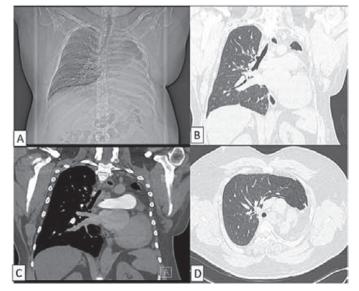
CT topogram (a) showing homogenous opacity of left hemithorax with non-bifurcation of trachea with mediastinal shift and contralateral herniation of right lung. (b) CT coronal lung window (c) showing absent left lung with shift of mediastinal structures into left hemithorax (d) axial lung window settings
